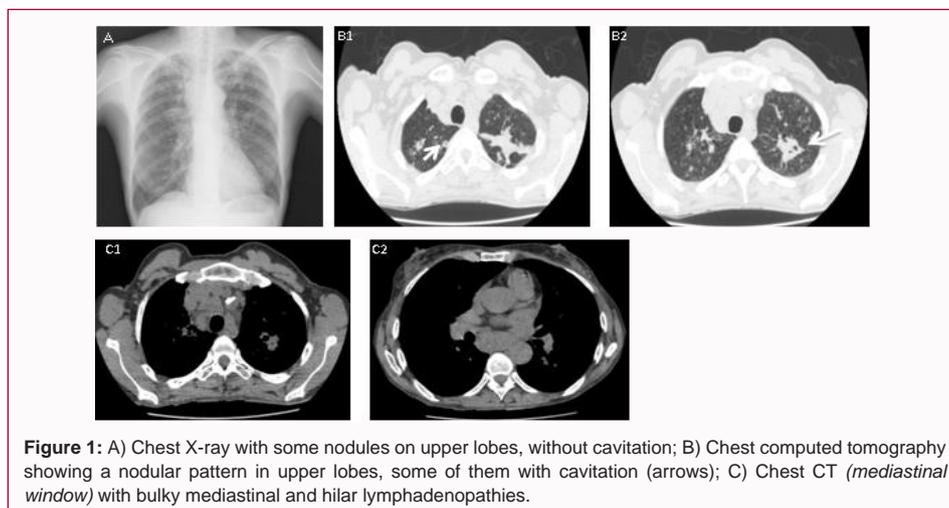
A) Chest X-ray with some nodules on upper lobes, without cavitation; B) Chest computed tomography showing a nodular pattern in upper lobes, some of them with cavitation (arrows); C) Chest CT (mediastinal window) with bulky mediastinal and hilar lymphadenopathies.
